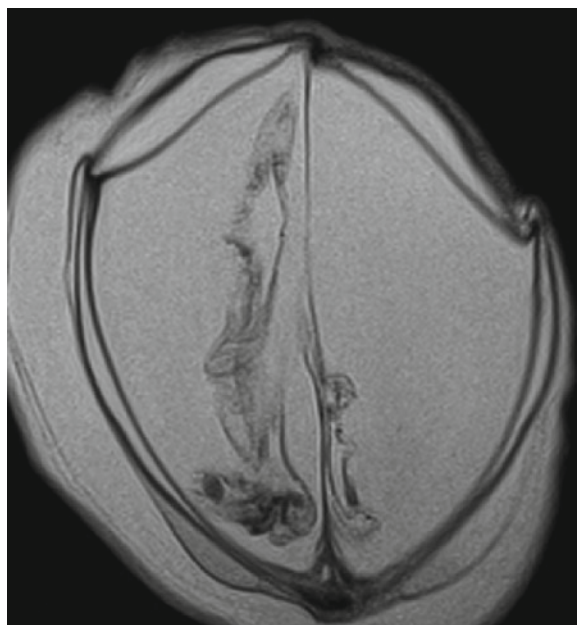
Axial MR image of 28-week gestation fetus with hydranencephaly. There is no parenchyma visible on this section. The meninges are seen and the choroid plexus within a fluid-filled space. In most cases there will be a small amount of fronto and occipital lobe present, often connected by a “basket handle” distribution of parenchyma seen on the midline sagittal view only (not shown)
